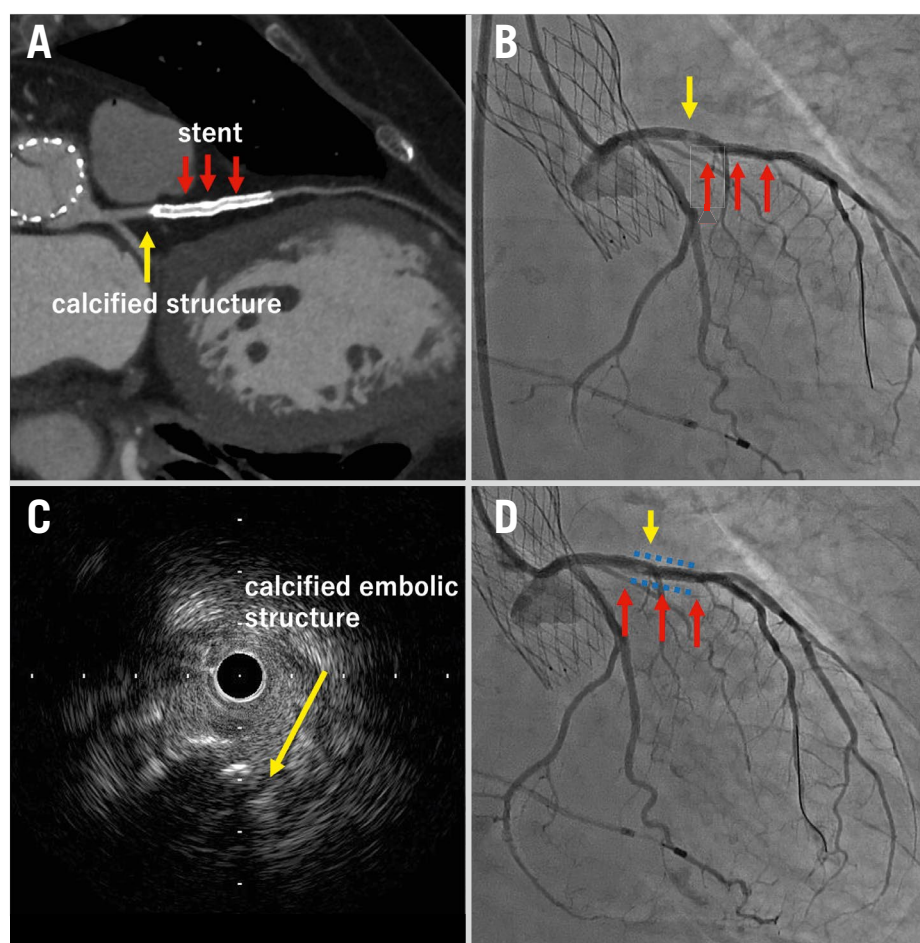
Imaging and angiographic findings. A) Emergent computed tomography imaging showed the calcified structure (yellow arrow) at the previously implanted stent (red arrows). B) Emergent coronary angiography showed the calcified embolic structure (yellow arrow) at the proximal end of the prior stent (red arrows). C) Intravascular ultrasound imaging confirmed the calcified structure (yellow arrow). D) Final angiography showing the bailout stent (blue dotted line).
